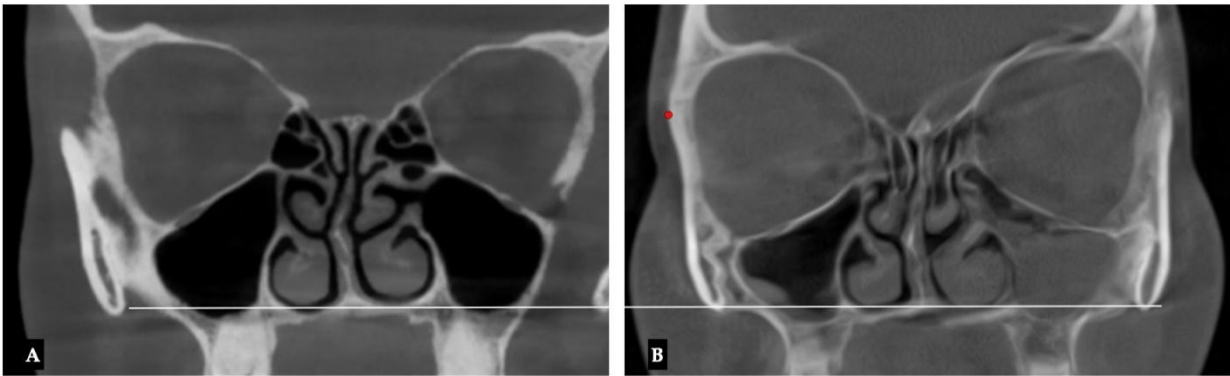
Pre-treatment (A) and twelve (12) months after completion expansion (B). Nasal base orientation relative to the alveolar processes and base of the skull. Both pre- and post-operative CBCT scans are oriented relative to the True Vertical Line (TVL) and Frankfurt Horizontal (FH).
